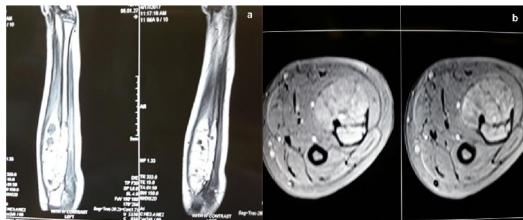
In axial and coronal MRI, the heterogeneous lesions of hyper intense signal in T1 and T2 were more consistent with vascular mass.
